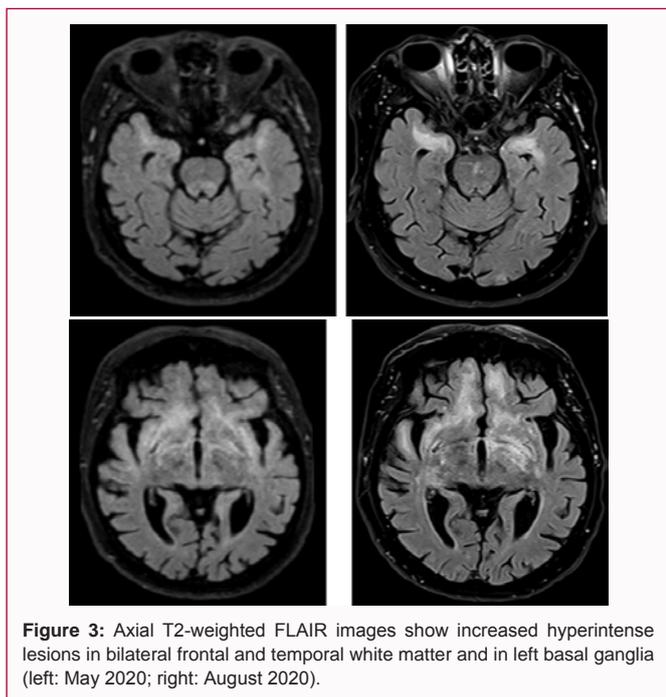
Axial T2-weighted FLAIR images show increased hyperintense lesions in bilateral frontal and temporal white matter and in left basal ganglia (left: May 2020; right: August 2020).
